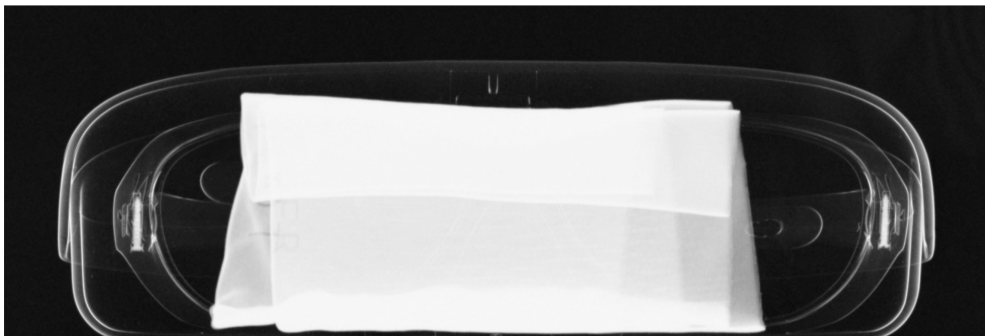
Imaging results of sunglasses and a cleaning cloth placed within a case obtained by X-ray grating interferometry. Three different but fully co-registered images can be extracted from the recorded stepping curves: the conventional attenuation contrast (a), the differential phase contrast (b), and the dark-field contrast (c).
